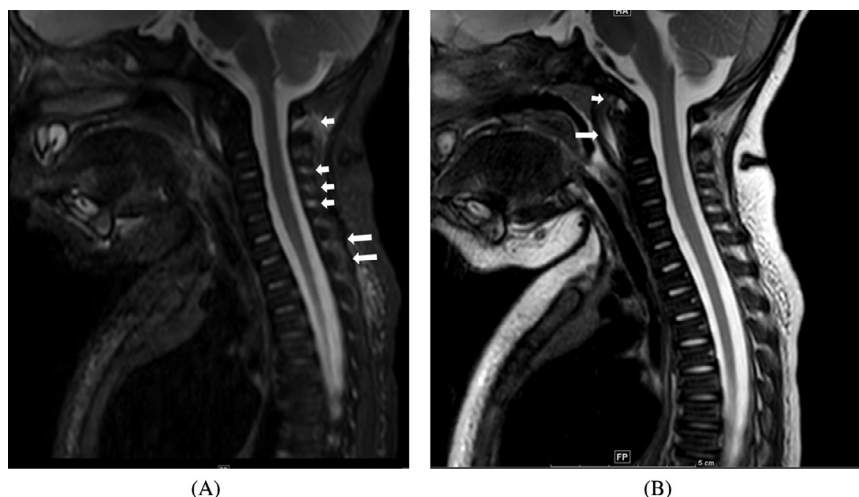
Ligamentous injury of the cervical spine. (A) STIR, and (B) T2, sagittal images from a cervical spine MRI examination of a 7 months old male (same patient as in Fig. 2) demonstrate ligamentous injury. There is high signal intensity at the interspinous ligaments (short arrows in figure A) and supraspinous ligaments (long arrows in figure A), as well as, in the anterior atlanto-occipital ligament and surrounding it (short arrow in figure B). There is also prevertebral edema at the cranio-cervical junction (long arrow on figure B). STIR = short tau inversion recovery.
